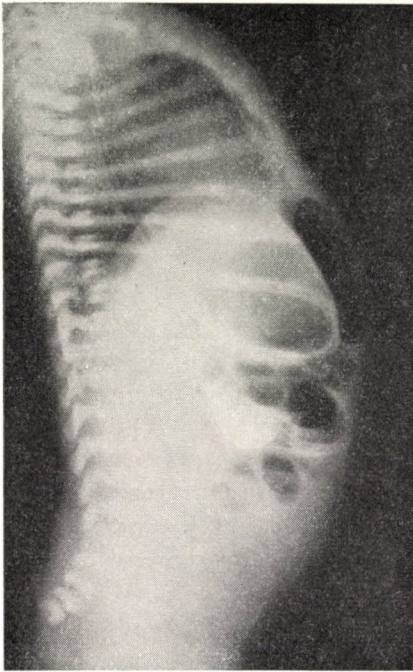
X-ray showing free air in abdomen, with fluid level in the recess
